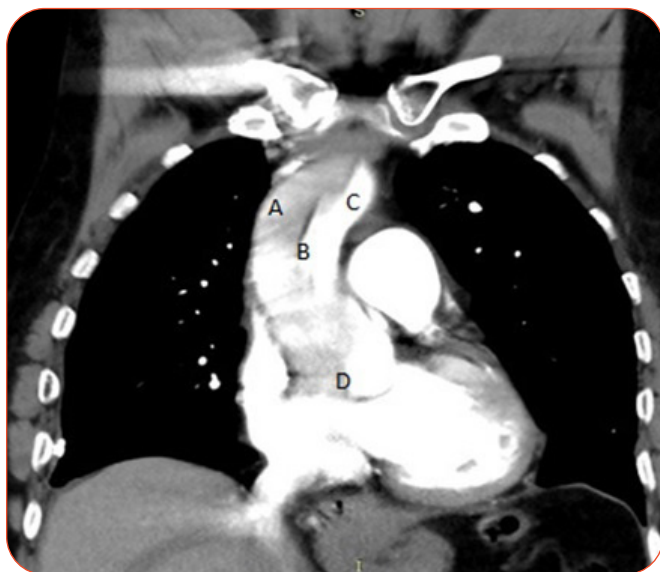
Coronal CT view of the chest demonstrating the false lumen (A), dissection (B) and true lumen (C) of the ascending aorta associated with the aortic root dilatation (D).
